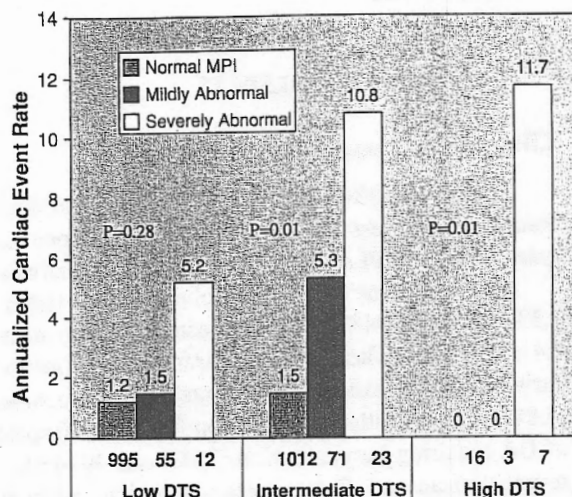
Risk stratification of DTS with SPECT-MPI. Risk stratification of DTS with gated SPECT-MPI. DTS, Duke treadmill score. Normal gated SPECT-MPI = SSS < 4; mildly abnormal gated SPECT-MPI = SSS 4-8; moderate-severely abnormal gated SPECT-MPI = SSS > 8.
